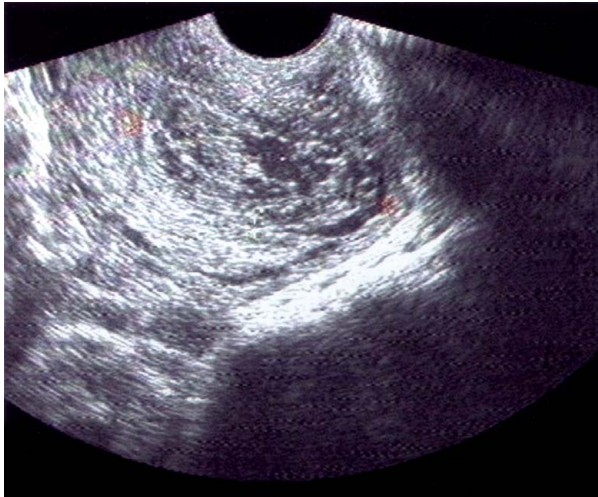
Transvaginal grayscale ultrasonography shows numerous tortuous anechoic structures over the fundal myometrium of the uterus.
